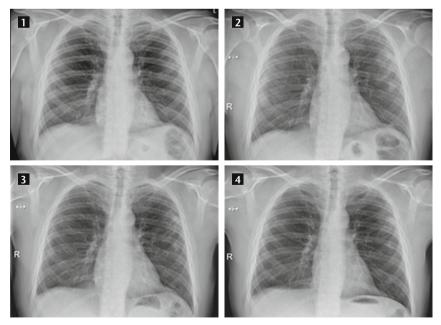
Radiological study of the patient. Chronological order: Chest X-ray number 1 corresponds to clinical day +4 and shows no pulmonary infiltrates. Chest X-ray number 2 corresponds to day +7 and shows a peripheral patchy infiltrate in the left lobe. Number 3 corresponds to day +8 and number 4 to day +9 and shows a progressive radiological improvement, with attenuation of the pulmonary patches.
